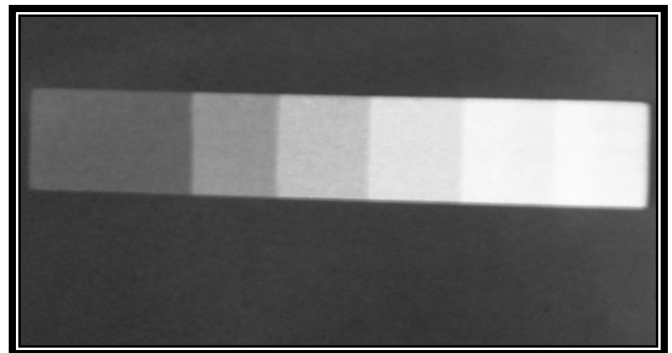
Radiograph of aluminum step wedge showing the radiological differentiation among various grades
